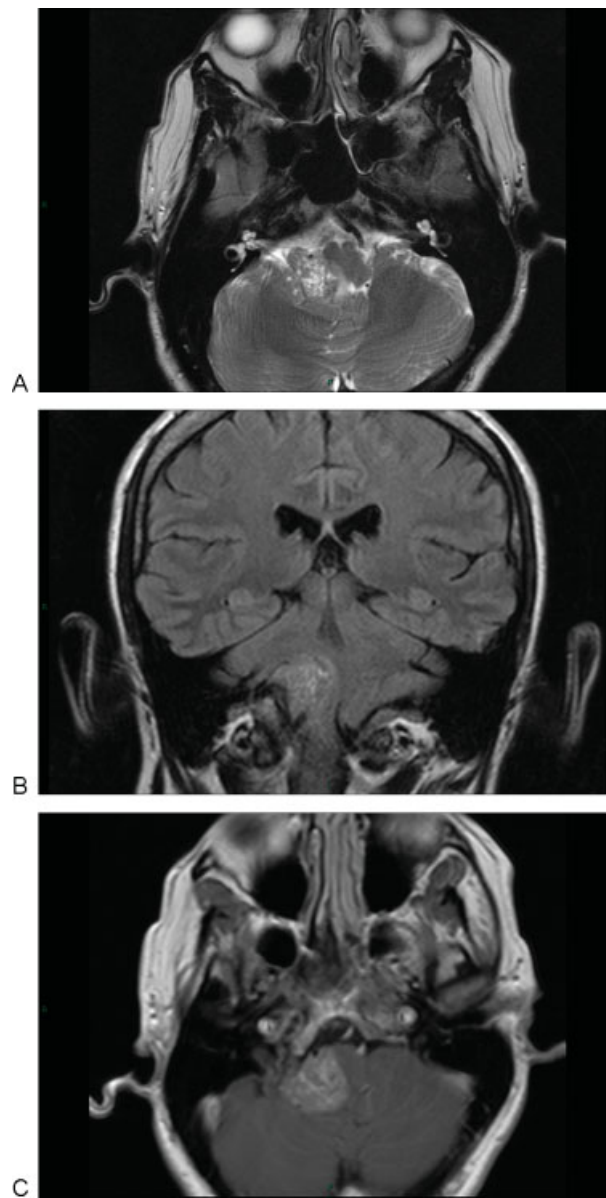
Magnetic resonance imaging scan of primary cerebellopontine angle melanocytoma. (A) Axial T2 image showing a right cerebellopontine angle (CPA) isointense mass and areas of hypo and hyper intensity. (B) Coronal T1 image showing a right CPA mass displacing the brainstem. The lesion was slightly hyperintense with areas of isointensity. (C) Axial T1 with contrast demonstrating mild homogeneous enhancement.
